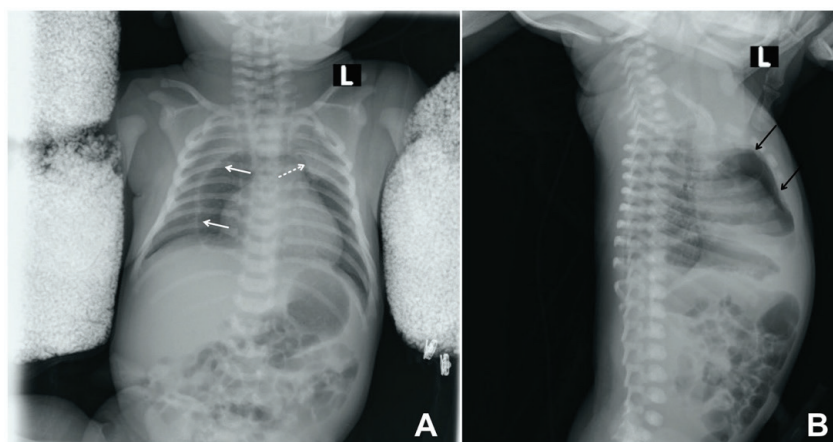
(A) AP chest radiograph shows well-defined radiolucent band framing the right border of the heart, extending from superior mediastinum to right hemidiaphragm with a crescent shaped homogeneous opacity peripherally representing displaced thymic lobe and compressed lung parenchyma (white narrows), the left lobe of thymus is lifted off the heart (white dashed narrow). (B) Lateral chest radiograph reveals retrosternal air collection (black narrow).
